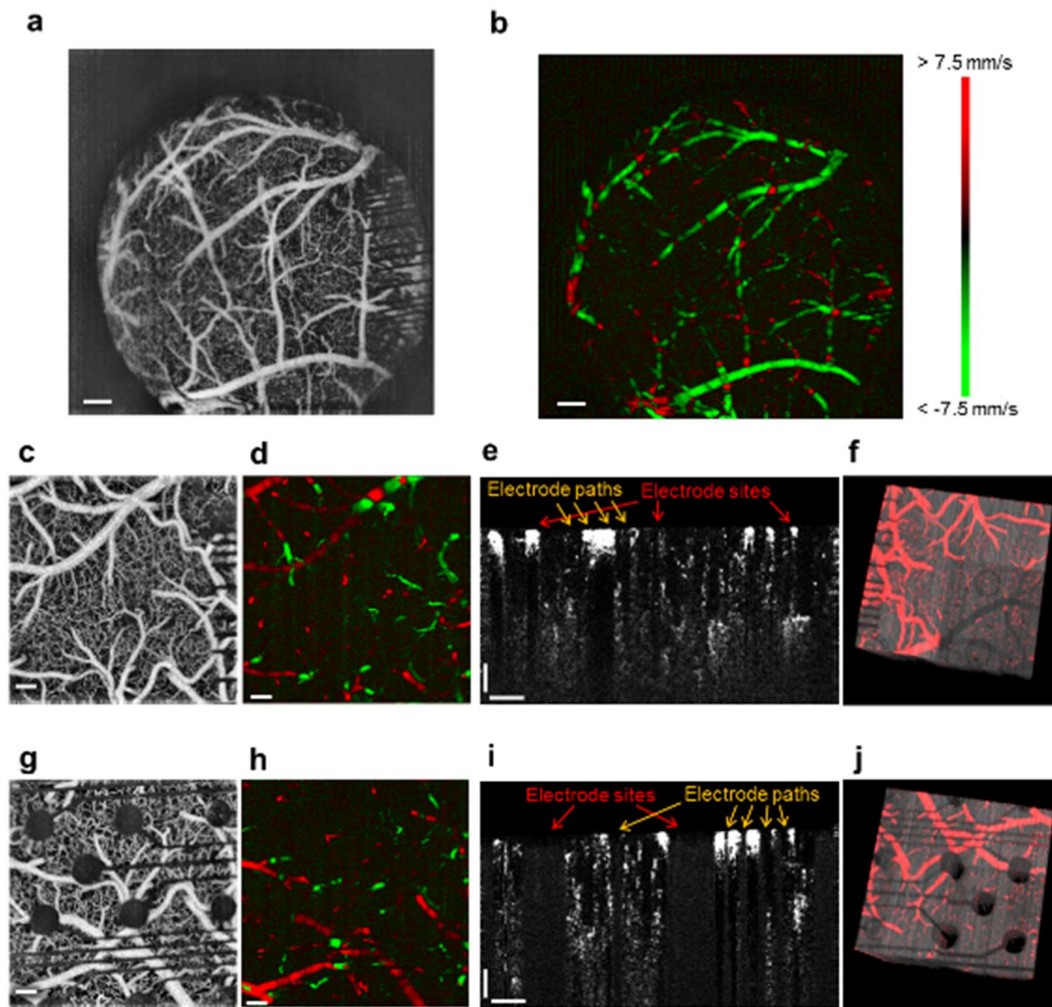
Optical coherence tomography through CLEAR and platinum devices. (a) and (c) Maximum intensity projection (MIP) of OCT angiogram showing cortical vasculature visible through the CLEAR micro-ECoG device (FOV  $2.8 \times 2.8 \text{ mm}^2$  and  $1.1 \times 1.1 \text{ mm}^2$ , respectively). (b) and (d) Doppler blood flow velocity image showing the directionality of blood flowing through the vasculature below the CLEAR device (FOV  $2.8 \times 2.8 \text{ mm}^2$  and  $1.1 \times 1.1 \text{ mm}^2$ ). Red color represents blood flowing towards the lens and green color represents blood flowing away. (e) Cross-sectional angiogram after contrast enhancement and de-shadowing (CLEAR device) (f) 3D visualization of the vasculature (red color) overlaid on the structural data (gray) (CLEAR device). (g) MIP of angiogram through a platinum micro-ECoG device, (h) Corresponding Doppler blood flow velocity measurements, (i) Corresponding cross-sectional angiogram, and (j) Corresponding 3D visualization of vessel structure for a micro-ECoG array with platinum electrode sites.
